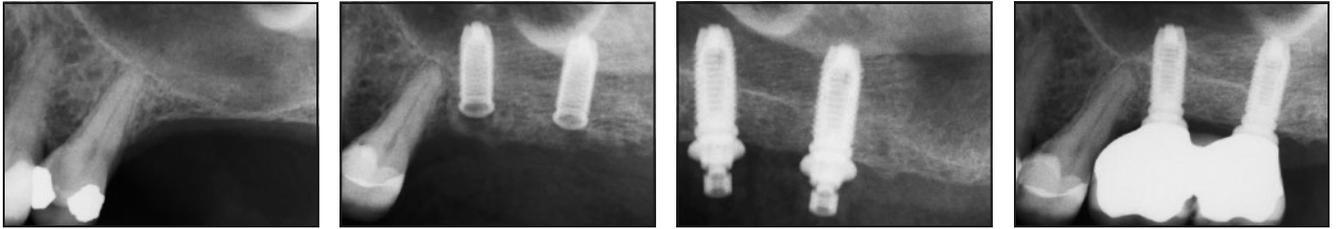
Case 1: Radiographic exams at 60-month follow-up.
